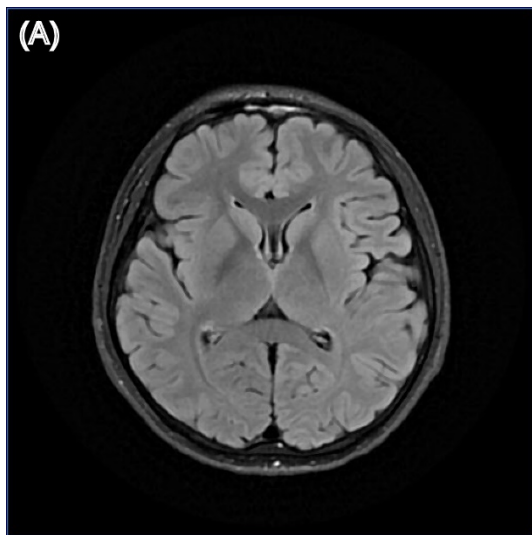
Structural brain MRI images of patient 28. (A) T2-weighted fluid-attenuated inversion recovery (T2-FLAIR) image; (B) Gadolinium-enhanced T1-weighted (Gd-T1w) image.
